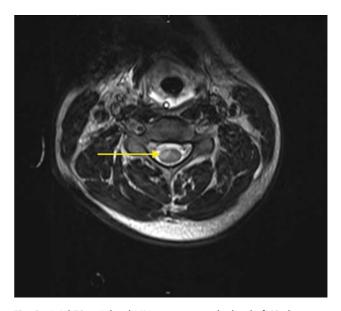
Axial T2-weighted MRI sequence at the level of C3 shows hyperintensity with restricted diffusion.
